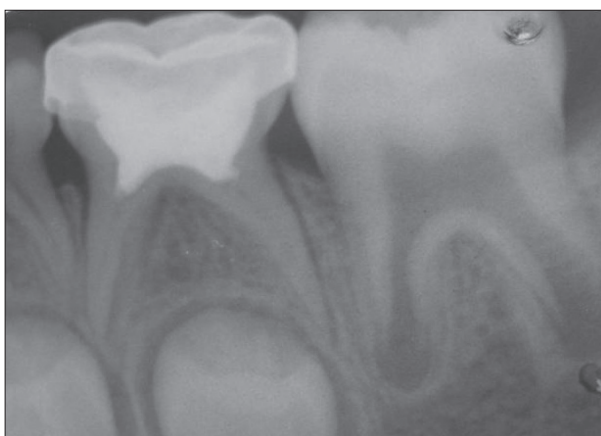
Thirty-six months post-operative radiograph for MTA pulpotomized tooth (85)
